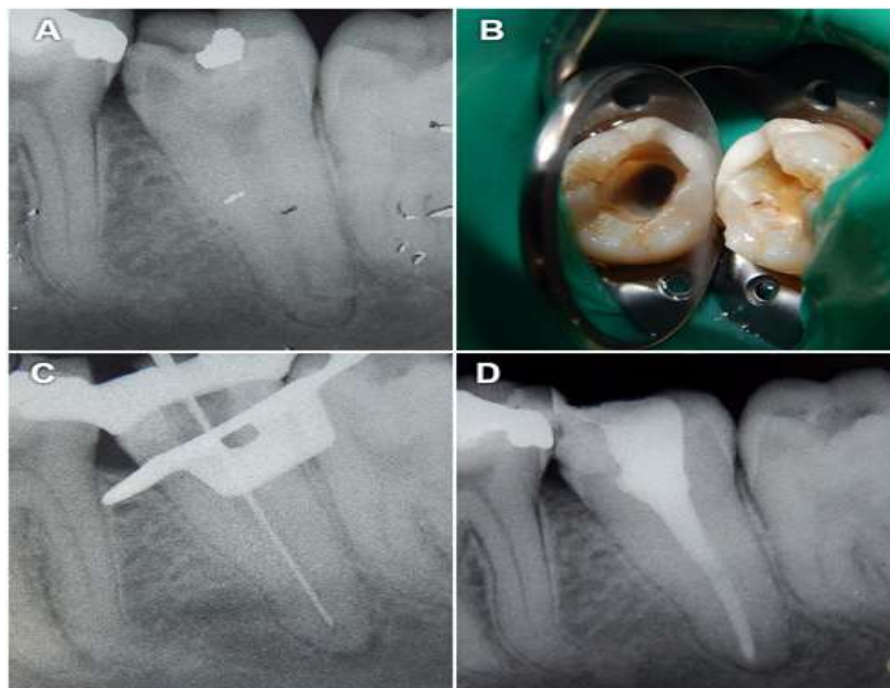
(A) Preoperative radiograph; (B) Clinical photograph; (C) Working length radiograph; (D) Obturation radiograph
